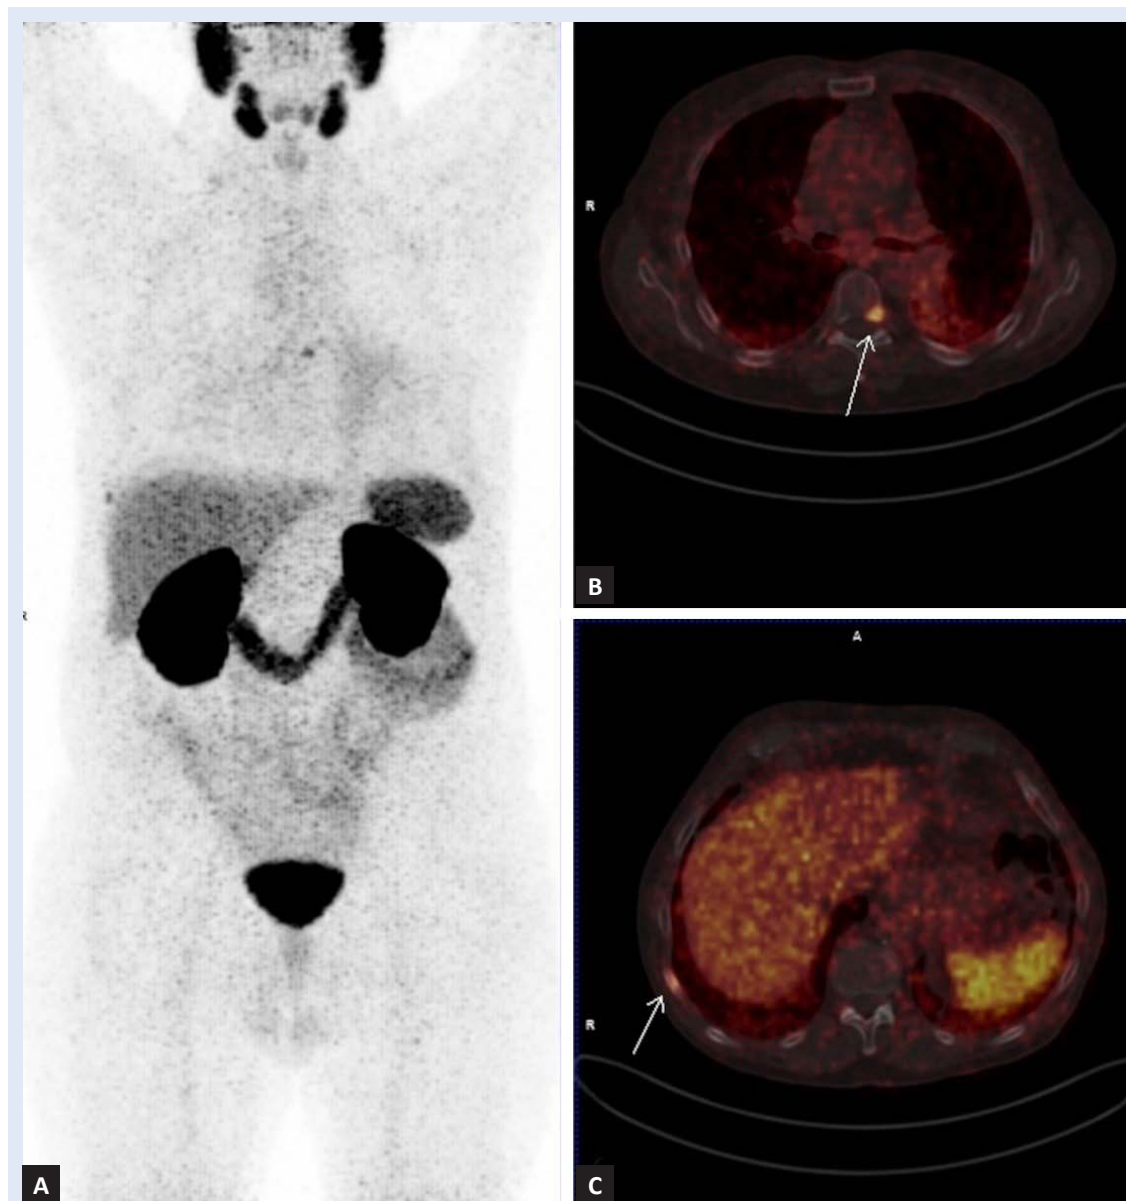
Gallium-68 PSMA-11 PET/CT imaging of 69 years old patient referred two years after radical prostatectomy due to biochemical recurrence (PSA 0,86 ng/ml), demonstrating bone metastases. A: Whole body MIP (Maximum intensity projection) PET image, B-C: Axial PET/CT images showing high PSMA uptake in Th7 vertebra and in 9th right rib. From the archives of the Clinical Department of Nuclear Medicine and Radiation Protection, University Hospital Centre Zagreb, Zagreb, Croatia.
